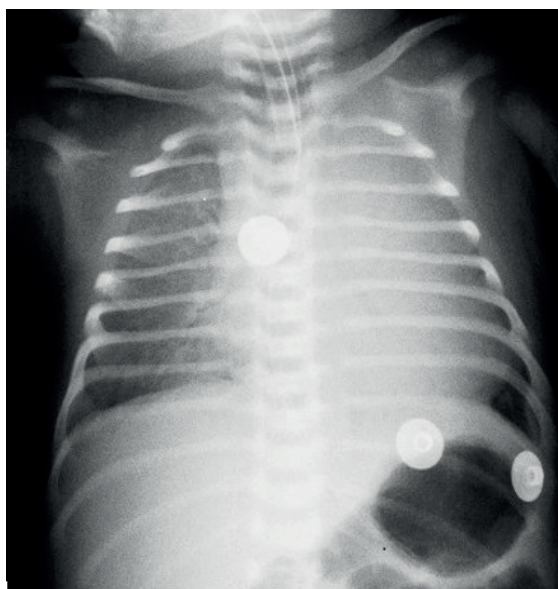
Cardiomegaly and pulmonary interstitial infiltration on X-ray of the newborn.
